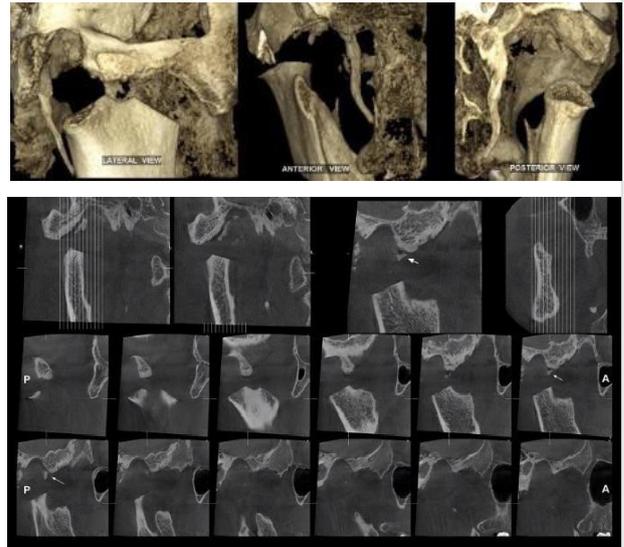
CBCT image After condylectomy
